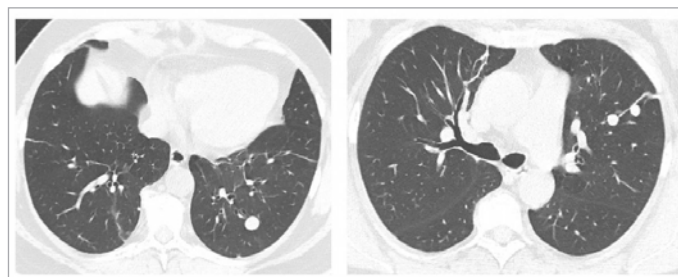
Foci (metastases?) in the V, IX, X segments of the left lung with a diameter of 5.2 mm, 5.2 mm, 13 mm by computed tomography.
